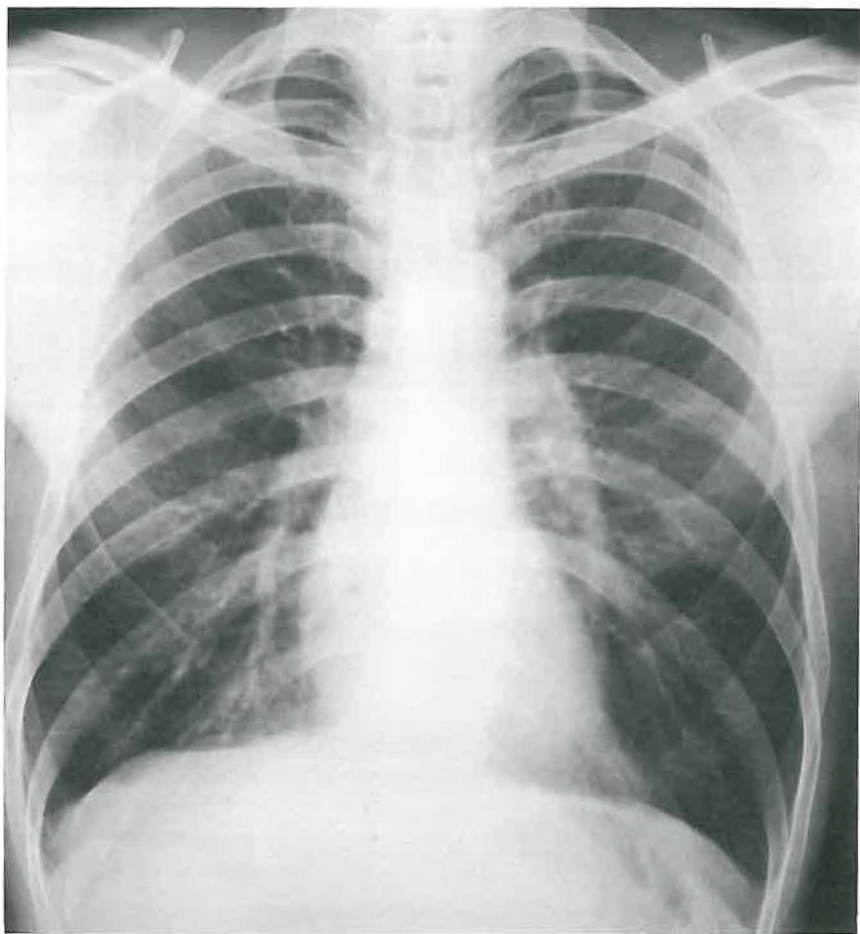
Soft-coal miner in whom there was no clinical or roentgenographic evidence of pneumoconiosis. Note the pattern of the major vascular components, arteries and veins. Many of the small vessels do not produce a pattern that can be seen. This chest study is characterized as Category 0.
